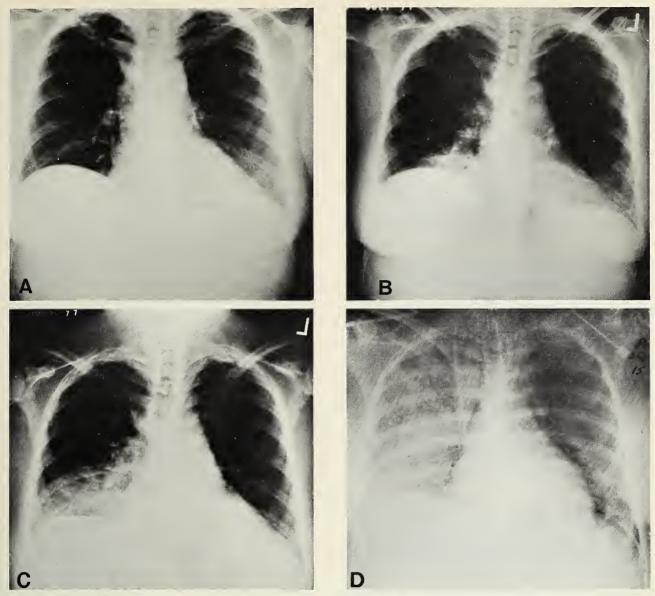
Chest roentgenograms obtained on admission (A), febrile day 4 (B), febrile day 8 (C), and febrile day 15 (D).
